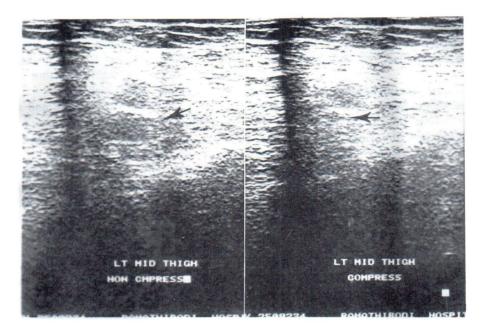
left - non compressed ultrasonographic study of the femoral vein at mid thigh right - compressed ultrasonographic study of the femoral vein at mid thigh showed completely collapsed venous lumen (arrow).
